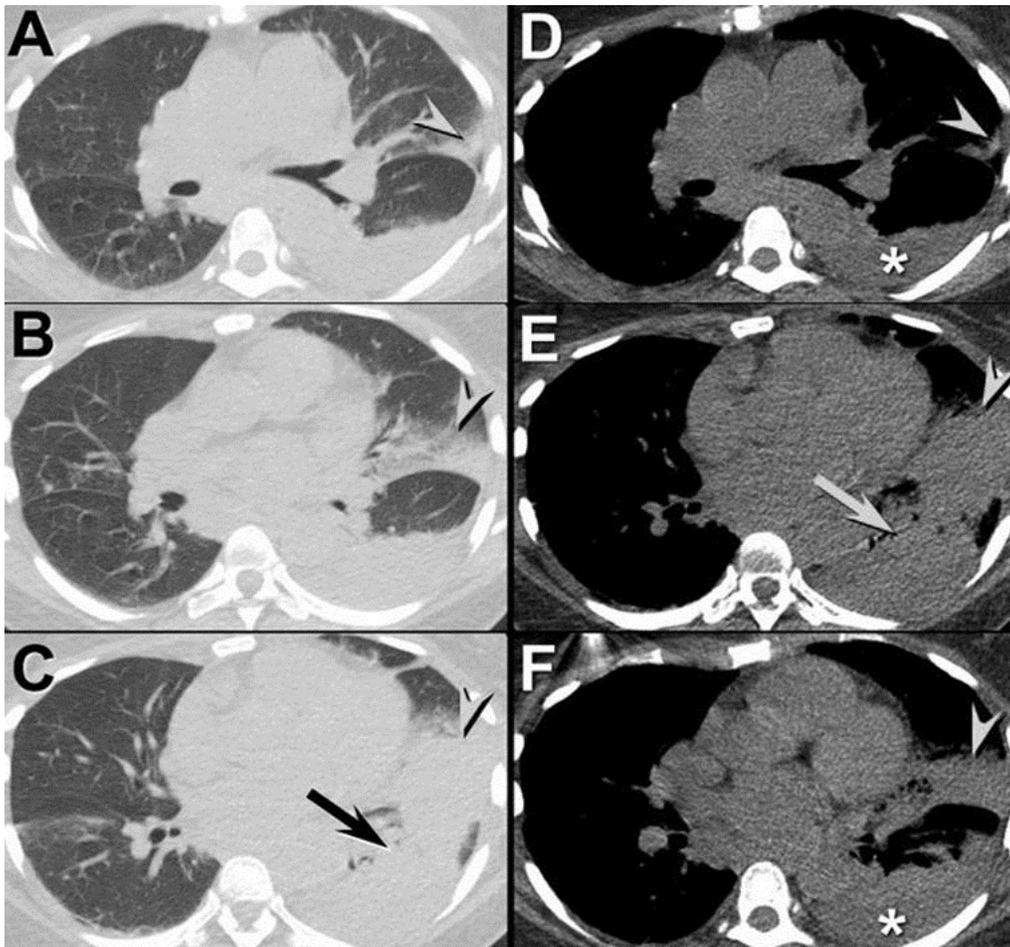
Axial unenhanced thoracic CT.
